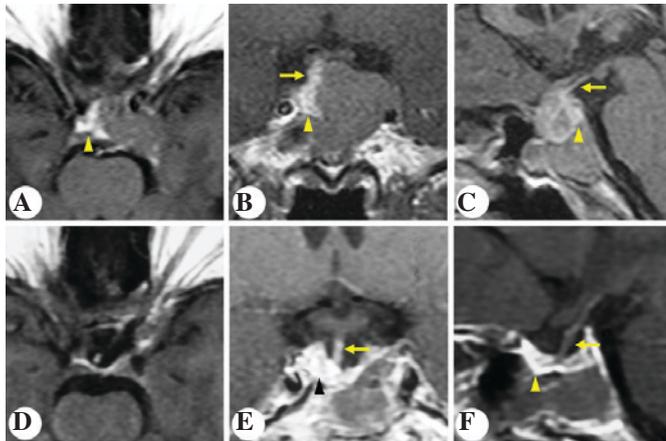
Patient 2*. Representative post contrast T1-weighted images. Preoperative (A) horizontal, (B) coronal and (C) sagittal and postoperative (D) horizontal, (E) coronal and (F) sagittal magnetic resonance imaging of the sellar region. Arrows indicate the pituitary stalk. Arrowheads indicate the pituitary gland.
